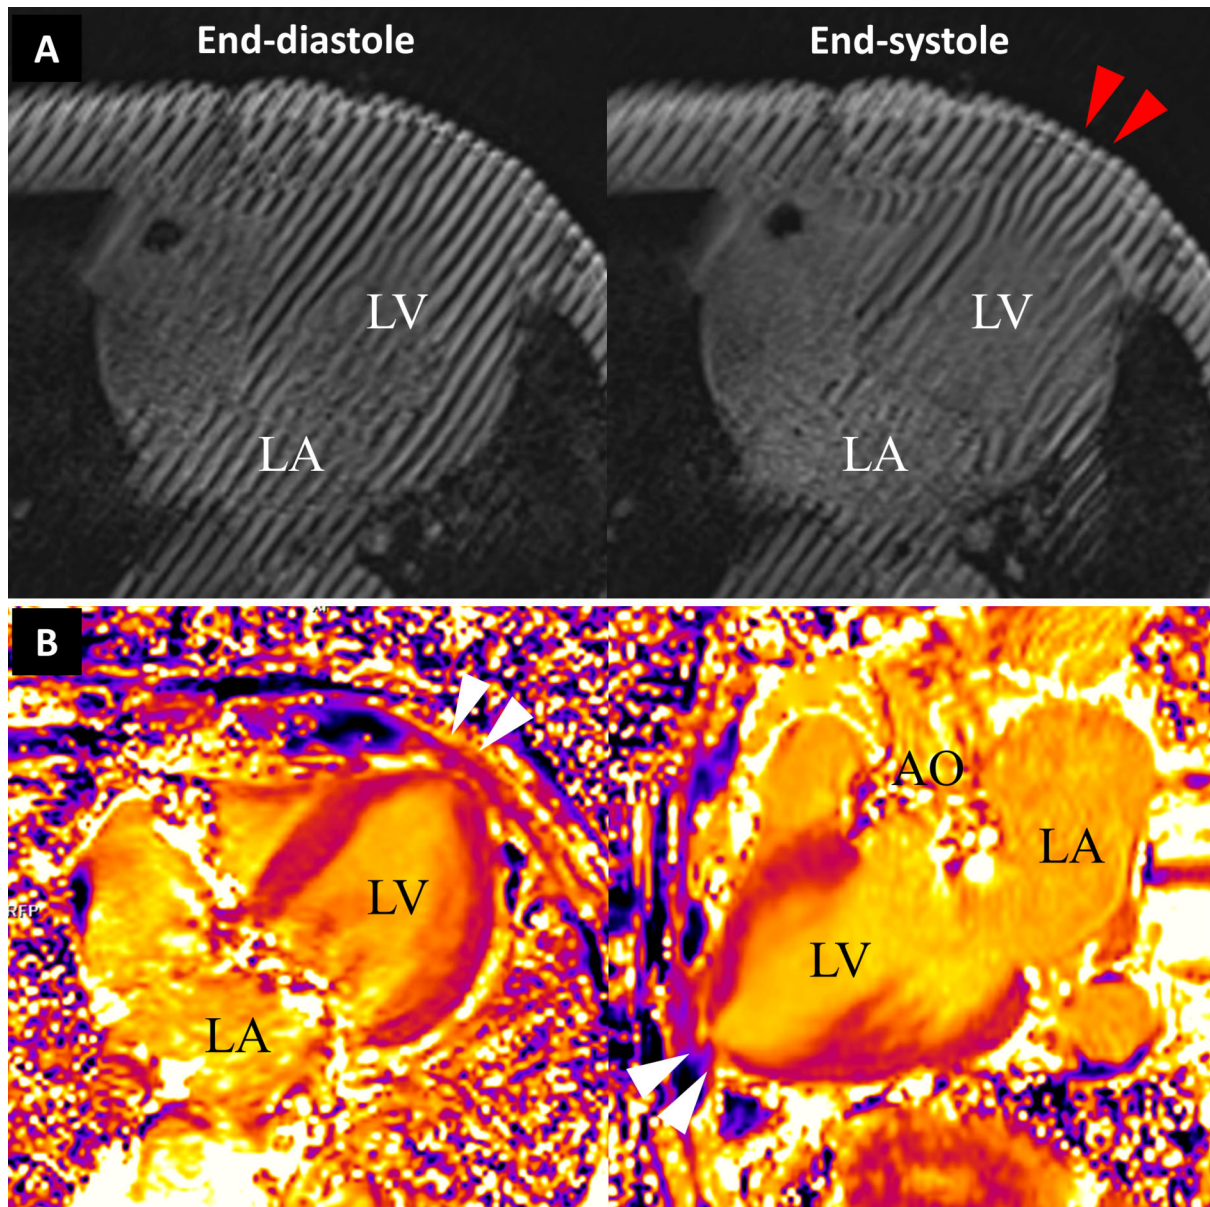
Non-contrast cardiac magnetic resonance images obtained after transapical transcatheter aortic valve implantation. (A) Tagged cine magnetic resonance images suggested adhesion of the left ventricular apical area (red arrowheads). (B) Color maps of the native T1 values demonstrated the localized thinning of the apex (white arrowheads). AO: aorta, LA: left atrium, LV: left ventricle
